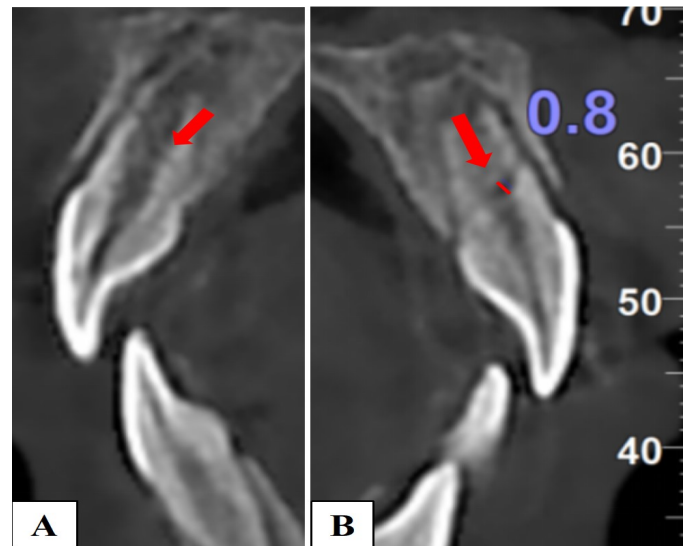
Preoperative CBCT image. (A) Oblique fracture line of tooth #11; (B) Oblique fracture line of tooth #21 and a 0.8 mm-width gap between the fragments.
